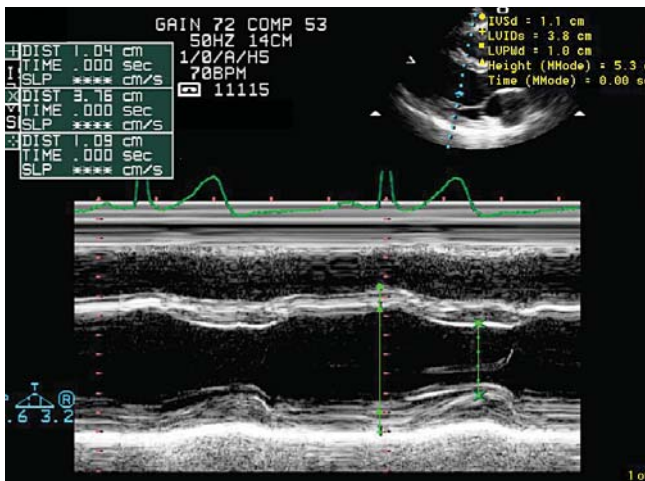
M-mode echocardiogram of the left ventricle showing septal and posterior wall thickness as well as LV end diastolic and LV end systolic diameters.
